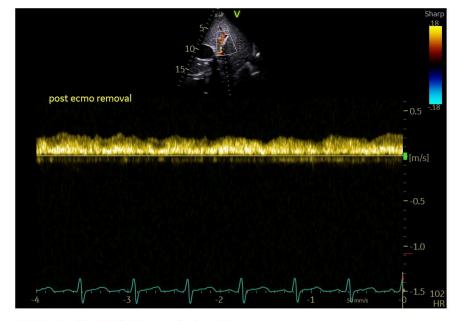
Post de-cannulation, Portal Vein Doppler
